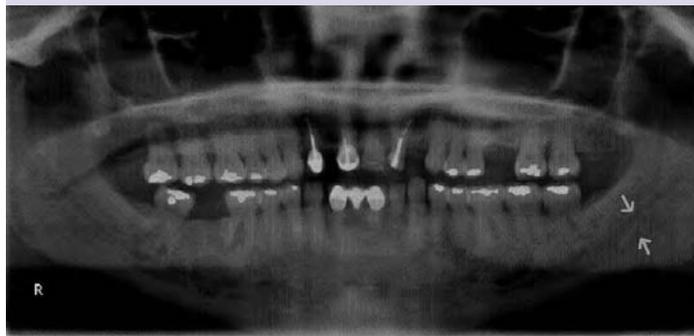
Panoramic X-ray revealed multiple radiolucent /radiopaque areas in right and left quadrants of mandible and suggestion of possibility of two inferior alveolar canals at left mandible.
